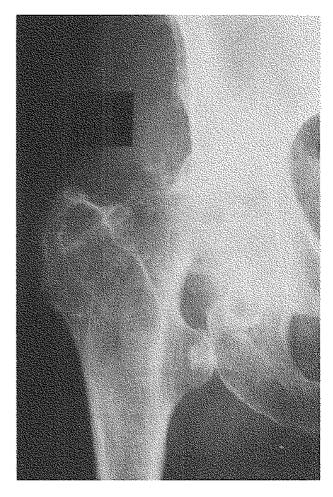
Radiograph taken on December 19, 1991.
